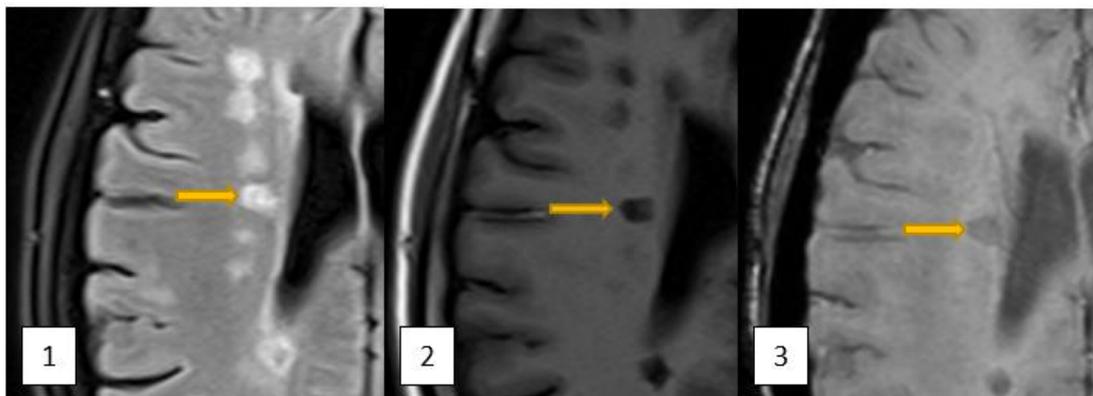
Hypointense SWI lesions. Axial FLAIR (1), T1W (2) and SWI (3). Arrow shows a FLAIR hyperintense periventricular lesion which appears as a black hole on T1W. On SWI, it is still seen as a hypointense lesion, whereas most other lesions seen on FLAIR are not visible.
